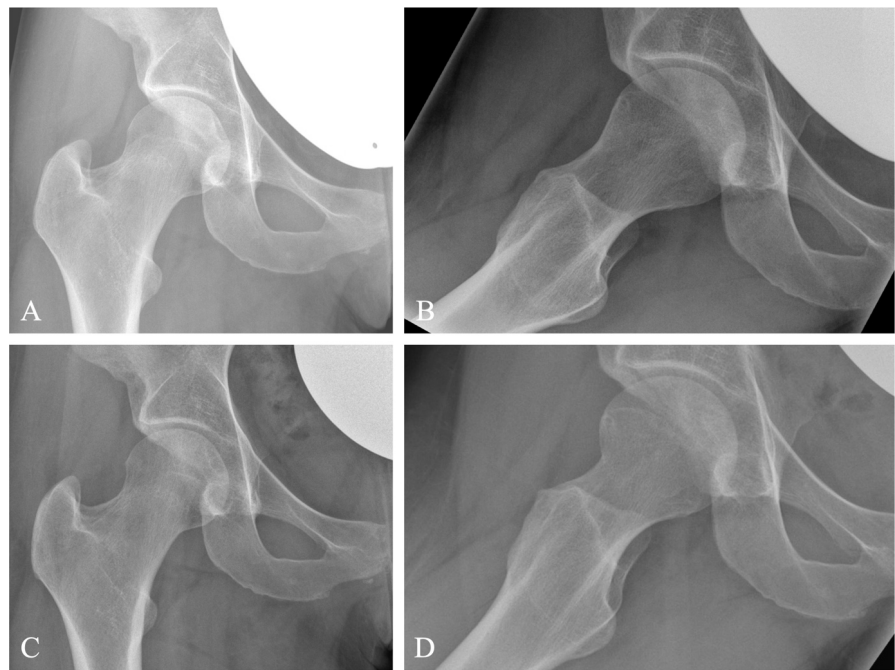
(A), (B): Preoperative x-rays of the right hip in ap (A) and axial projection (B). (C), (D): Postoperative x-rays after arthroscopic offset correction in ap (C) and axial (D) projection.
